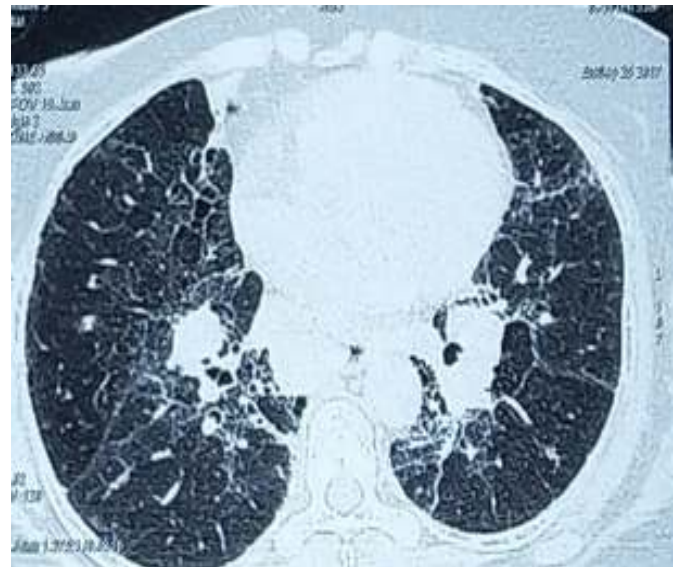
Axial section of High resolution CT scan of Thorax, lung window showing bilateral septal thickening and few areas of honeycombing
